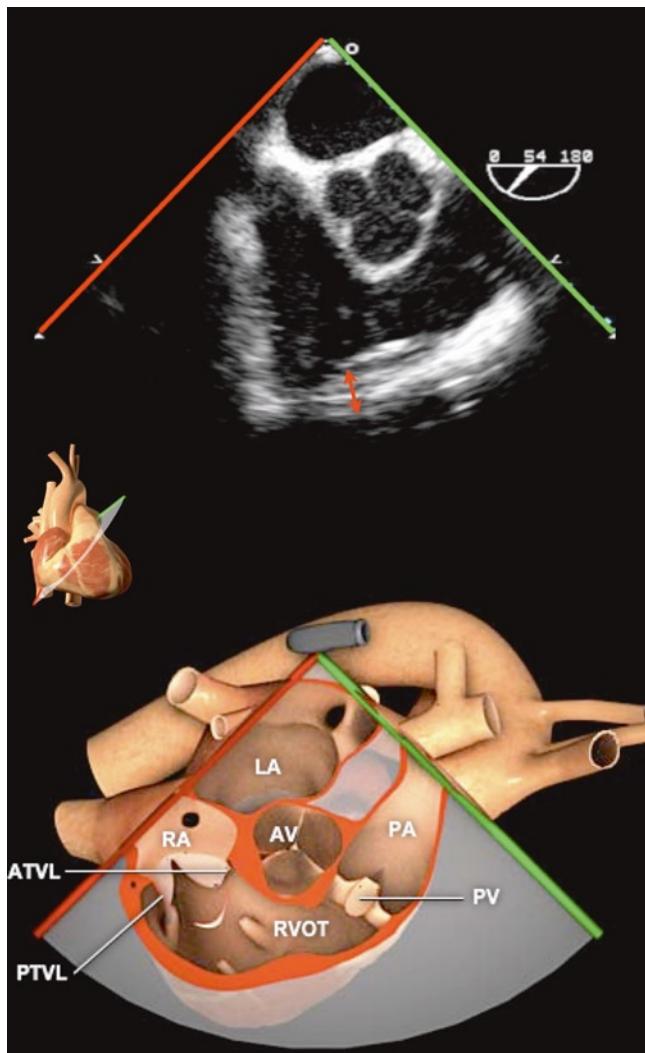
RV inflow-outflow view*. In this view, the ultrasound beam cuts the RV through its entire length. The arrow indicates RV wall thickness. (Photo is courtesy of Michael Corrin (<http://pie.med.utoronto.ca/TEE>)).
